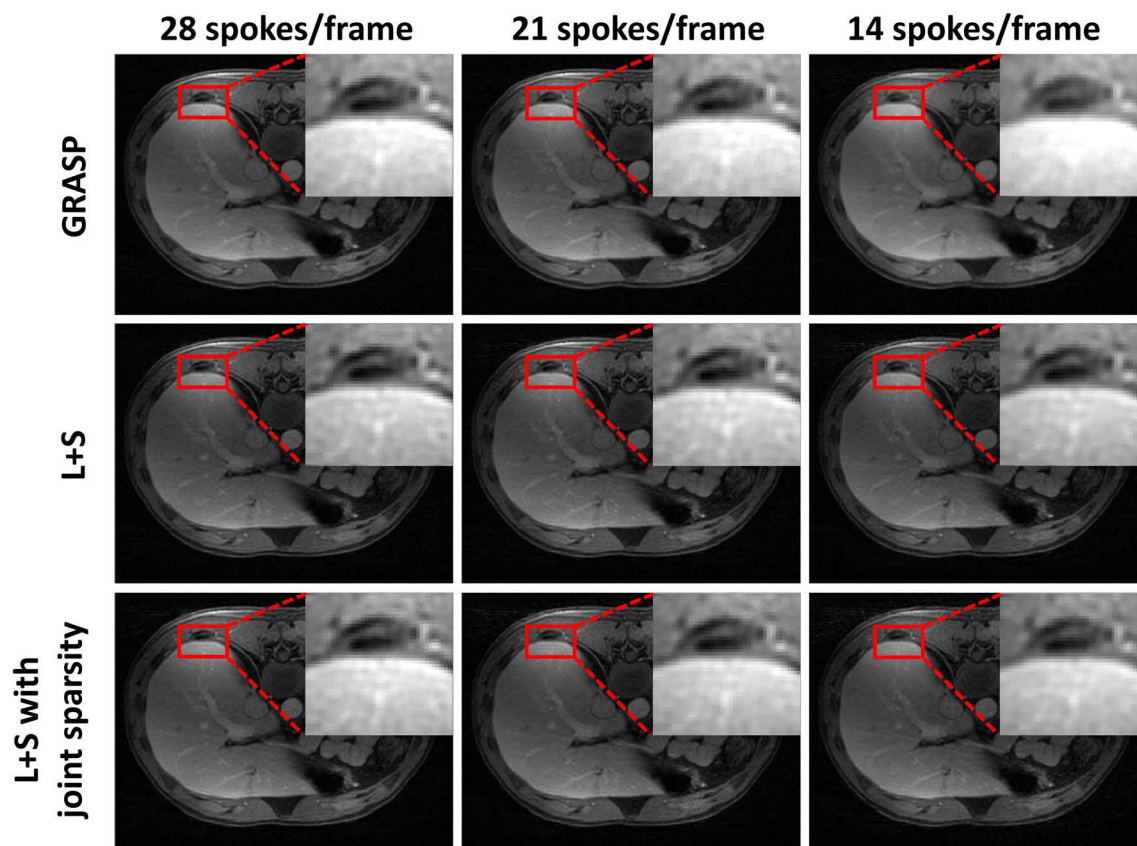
A comparison of the reconstructed images of GRASP, L+S decomposition, and L+S with joint sparsity at different temporal resolutions in the venous phase of the liver DCE-MRI dataset. A total of 21, 28, and 42 frames were reconstructed at different temporal resolutions, respectively. In the zoomed view of the liver section, blurring artifacts and degradation of tissue contrast were observed in GRASP. Less blurring artifacts and degradation were observed in L+S with joint sparsity. The penalty factor for the three reconstruction schemes was set the same among all the reconstructions.
